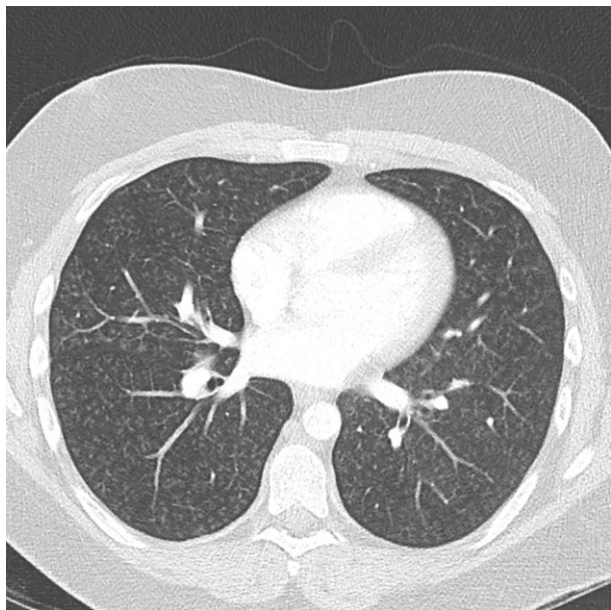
Computed tomography scan of the chest demonstrates widespread bilateral lung infiltrate, with centrilobular small nodules and tree-in-bud appearance peripherally, consistent with panbronchiolitis.
